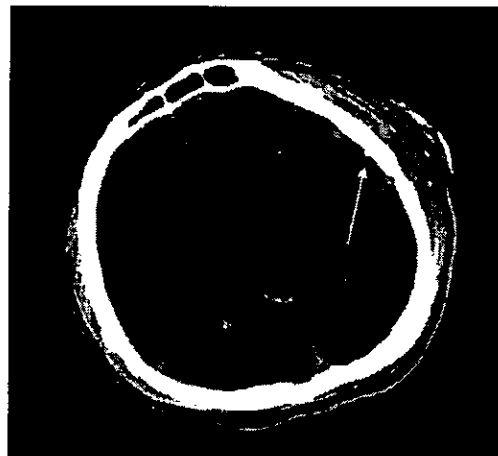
The location of the subdural CMS on CT scan. The white arrow shows the position of the sensor.
